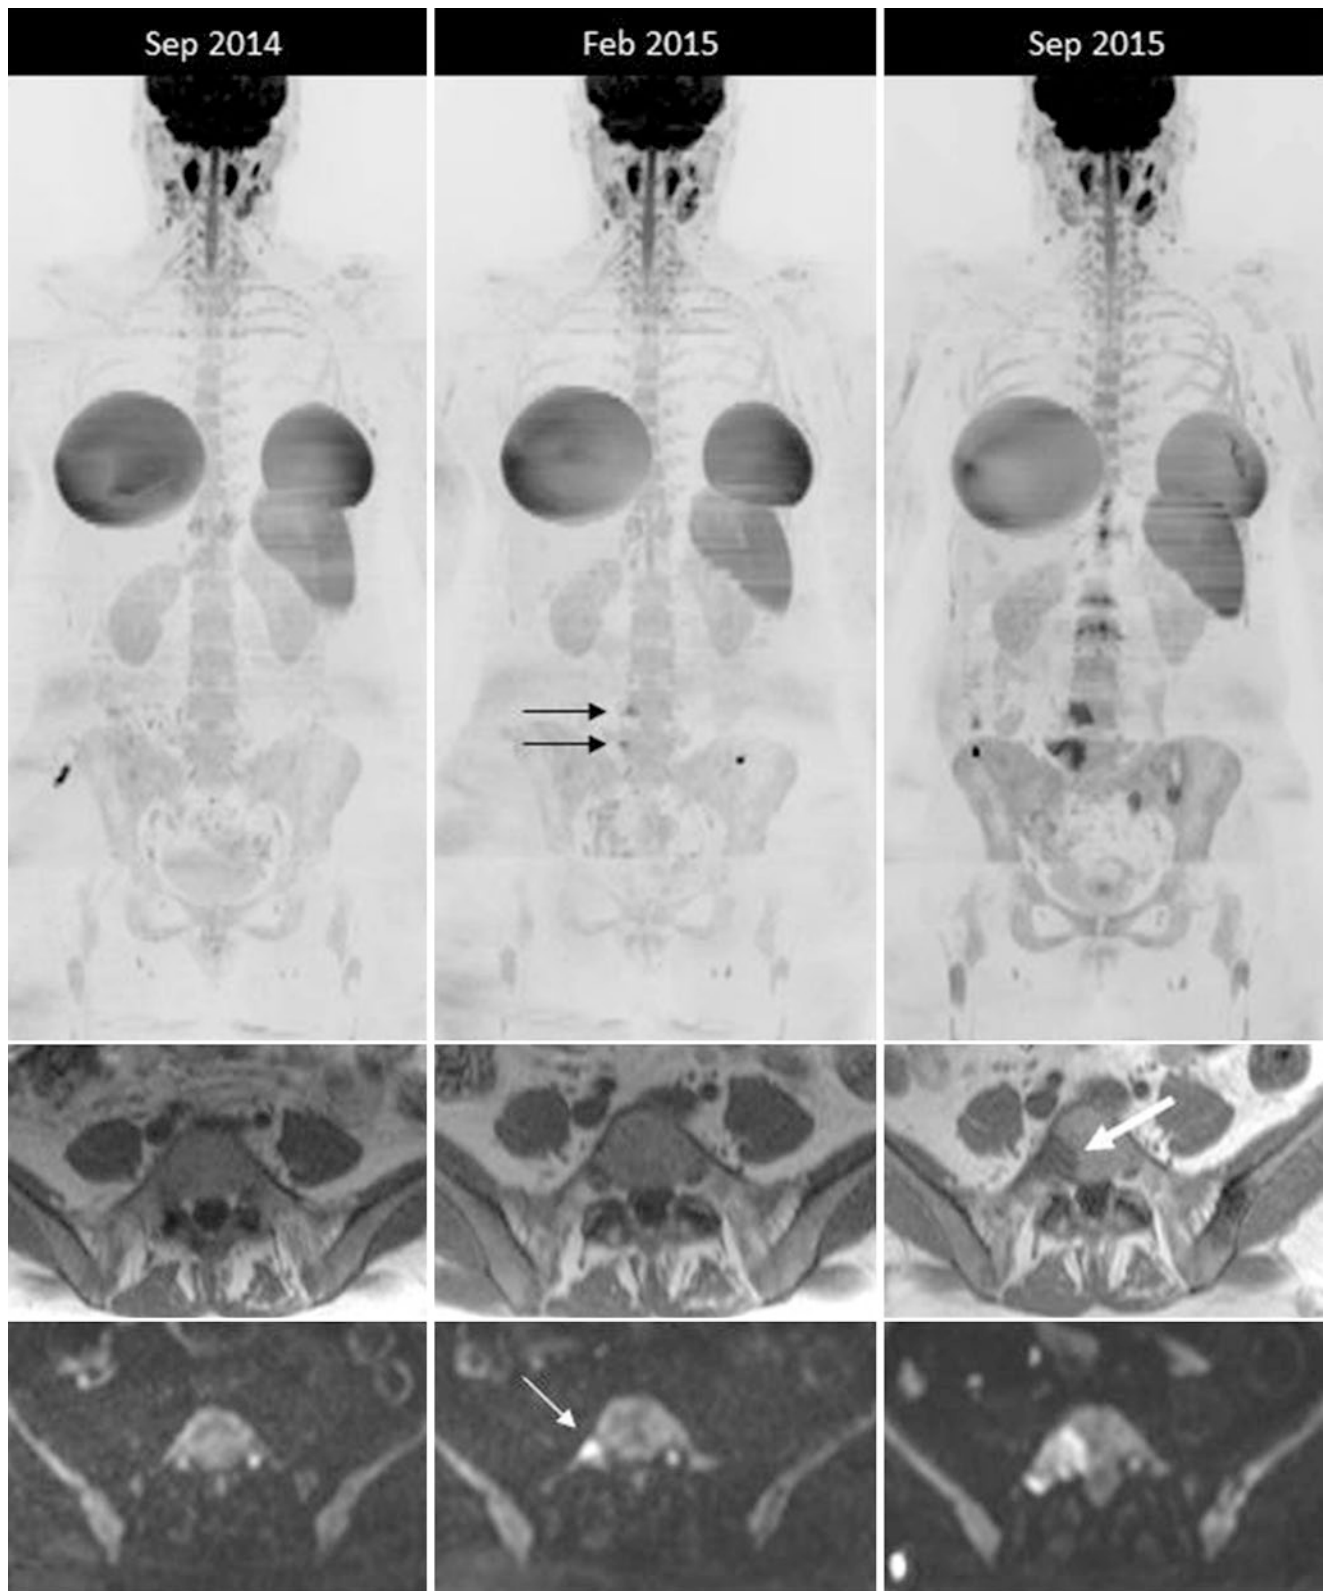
Bone disease progression in anatomical and diffusion-weighted images. Serial changes in a 39-year-old woman with progressive metastatic breast cancer being treated with hormonal therapy and bisphosphonates. Axial anatomical (T1W) and DWI images (b900) and inverted coronal MIP images allow bone metastases to be evaluated over time. The second scan shows bone disease progression with re-activation of lesions not visible in examination 1 (*black*
